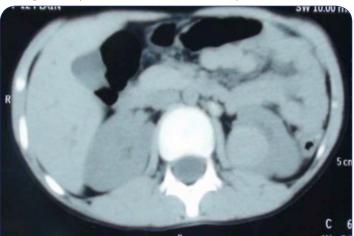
CT scan of abdomen showing 2.7cm X 2.3cm mass lesion in lower and mid-pole of left kidney with invasion of pelvicalyceal system.
